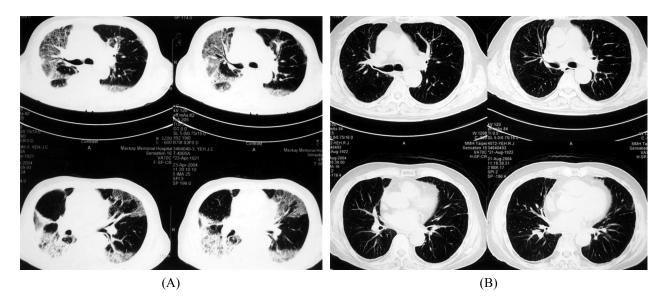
Chest CT: (A) initial, showing bilateral lower air-space consolidation, ground-glass opacities, and bronchial wall thickening and dilatation and (B) after 4 months of treatment with prednisolone.
